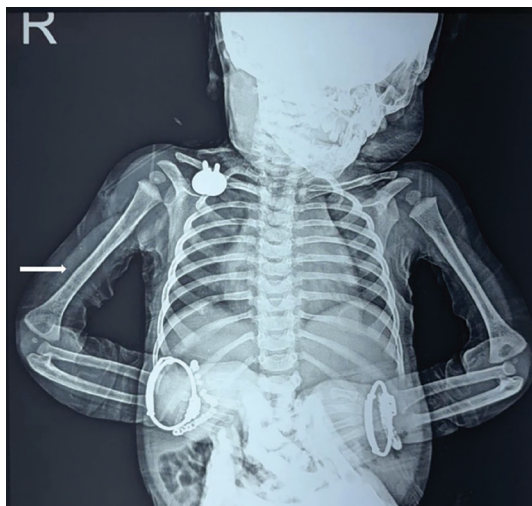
Follow-up X-ray after 6 months showing complete healing and excellent remodeling of the fracture mid-shaft humerus (arrow)
